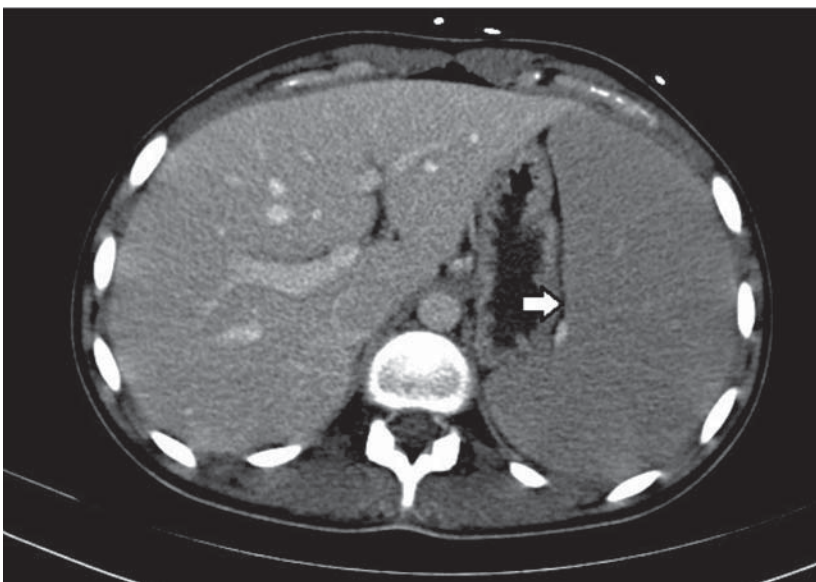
Abdomen computed tomography scan with arterial contrast enhancement. Demonstration of splenomegaly.
